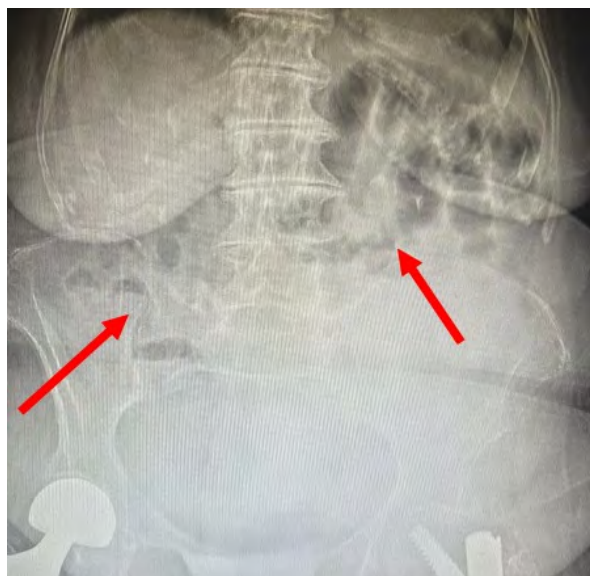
An abdominal X-ray showed short fluid levels and dilated gas-filled intestinal loops remaining in the mid-abdomen. Red arrows represent described changes
